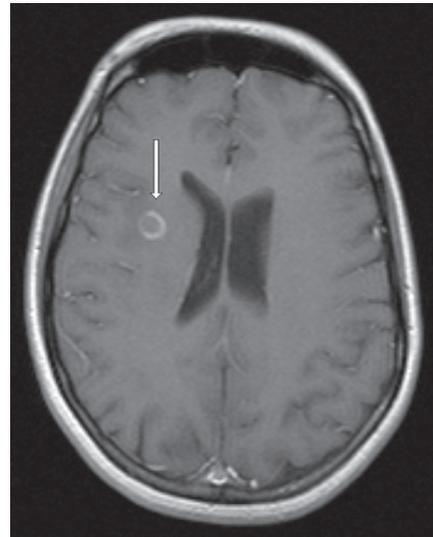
Axial T1-weighted image after gadolinium contrast showing an actively inflamed ring-enhancing lesion in a patient with multiple sclerosis.
